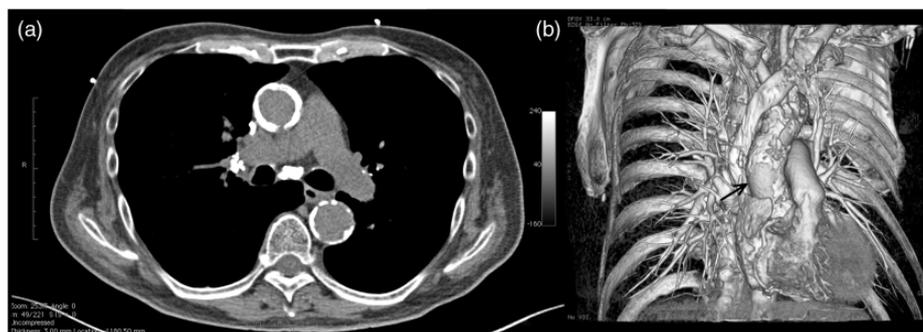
(a) Computed tomography confirmed severe diffuse vascular calcification and showed that the ascending aorta was virtually encased in calcium. (b) Three-dimensional computed tomography detected a safe spot (arrow) without calcification on the ascending aorta at 6 cm from the aortic annulus.
